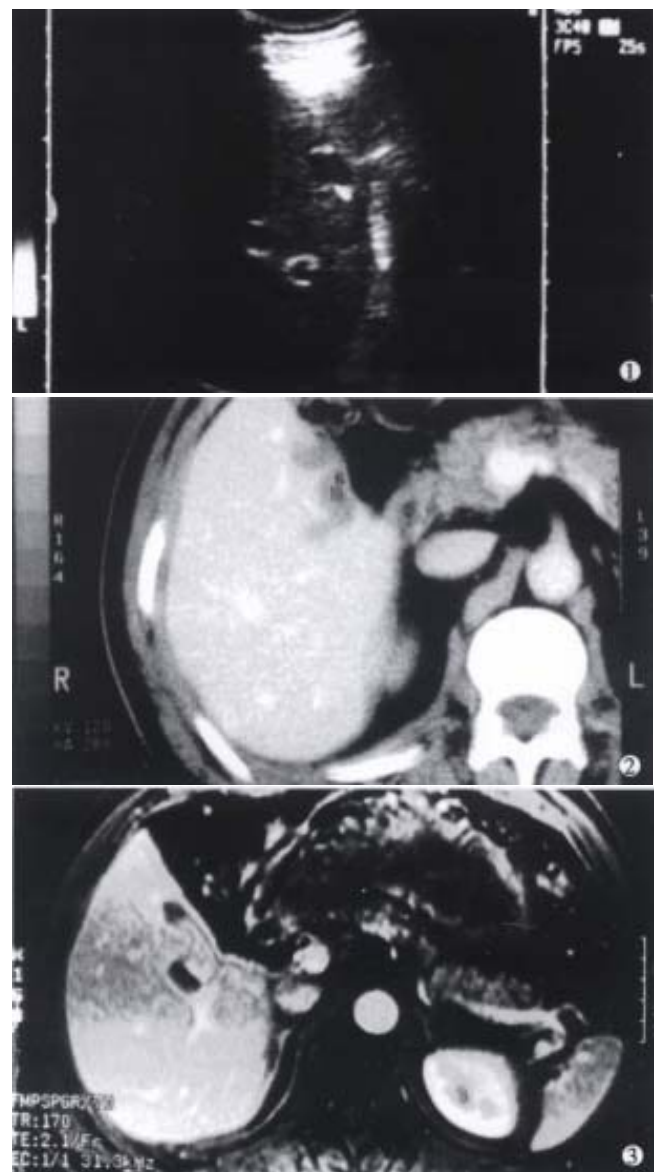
A nodule appeared as well-defined, hypoechoic and hypovascular irregular solid mass by ultrasonography.
